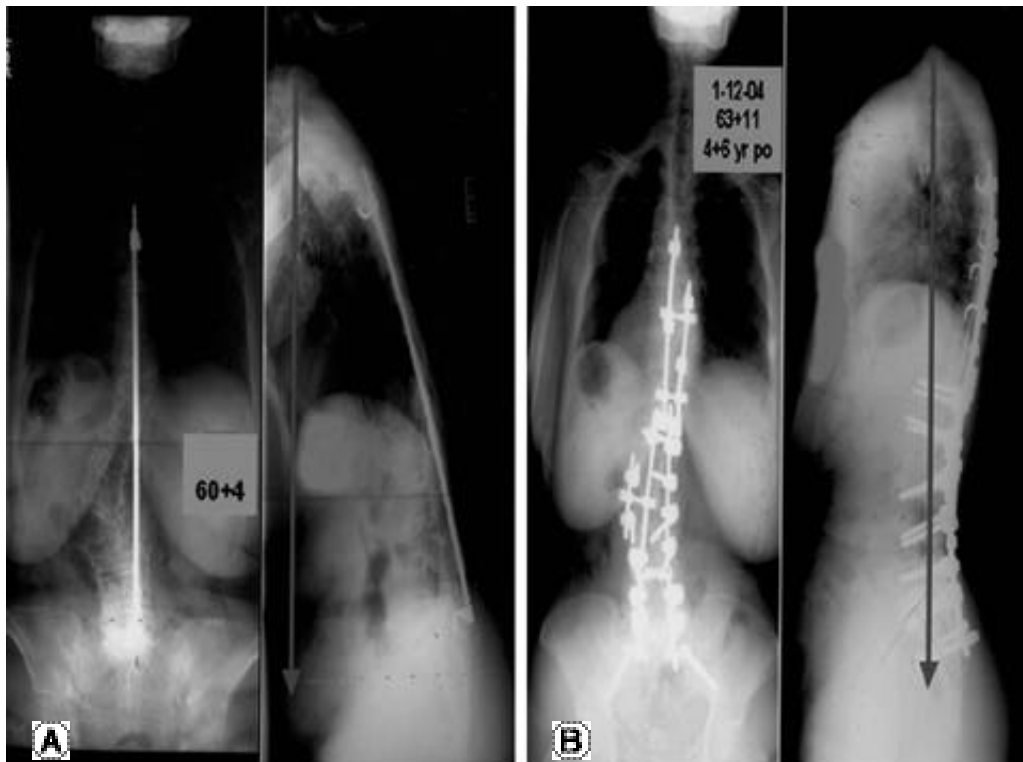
An example of preop and 4 year postop treatment of a fixed sagittal imbalance with a one-level pedicle subtraction osteotomy. multiple Smith-Petersen osteotomies. (A) Preoperative long-cassette standing coronal radiograph and sagittal radiograph (B) Post-operative long-cassette standing coronal radiograph and sagittal radiograph
